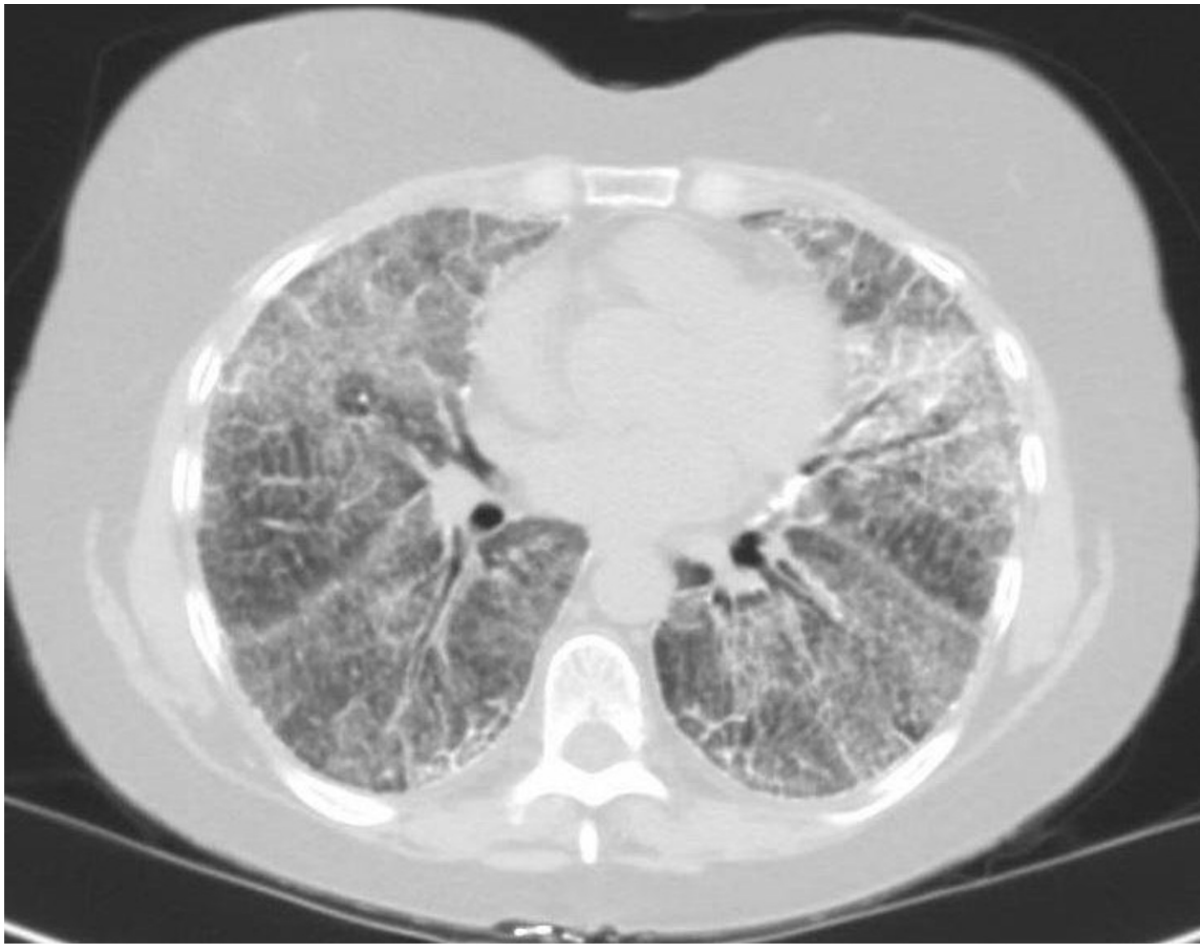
Chest CT of patient with pulmonary alveolar microlithiasis
